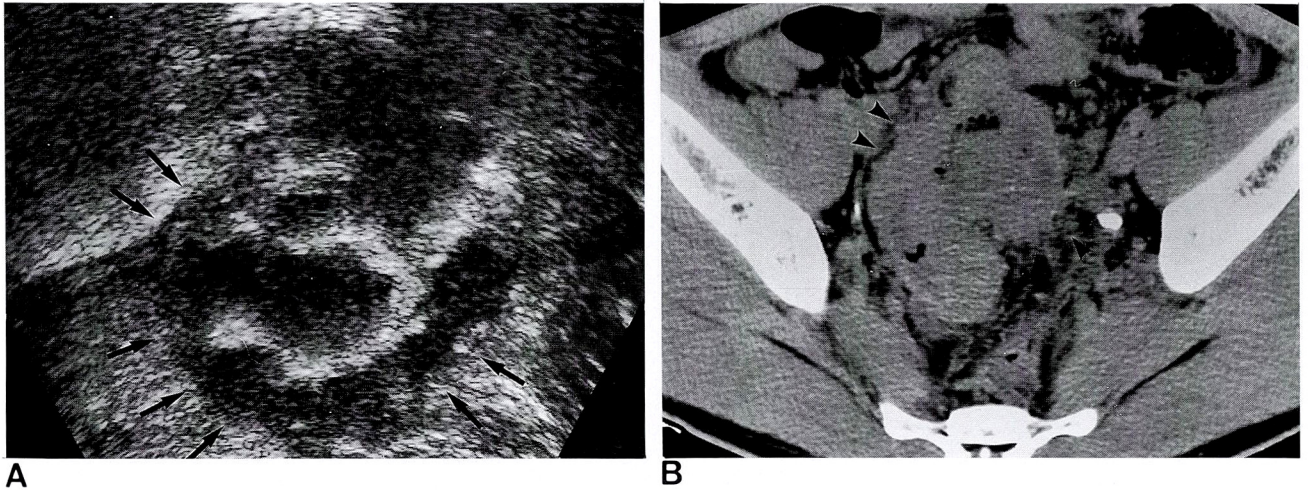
A 35 year old man with hematochezia. A. The ultrasonogram shows obliterated bowel wall layer and low echogenic mass with irregular margin (arrows). B. The CT scan shows isoattenuated mass with irregular margin and perilesional fat changes (arrowheads). This case was sigmoid colon cancer.
